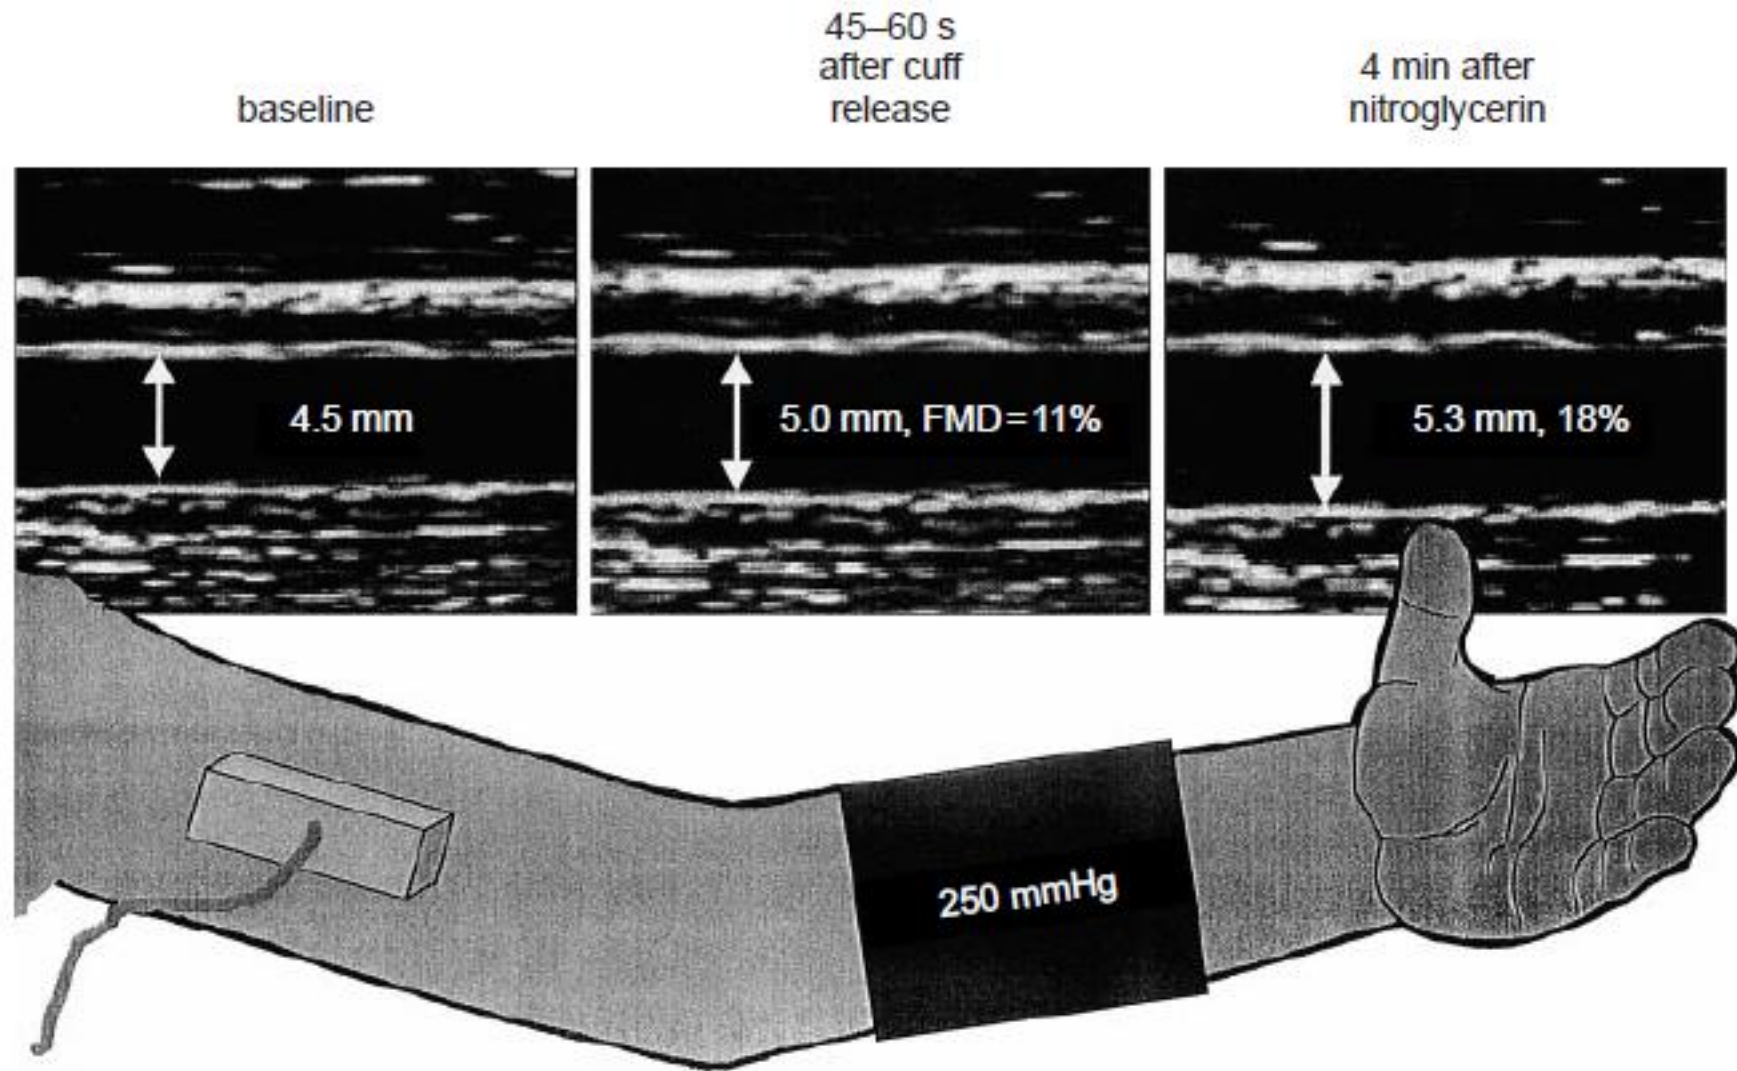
Brachial artery diameter is measured during three conditions; baseline (after at least 10 min supine rest), during reactive hyperaemia (induced by inflation to 250 mmHg and then deflation of a sphygmomanometer cuff around the forearm) and finally after the administration of sublingual nitroglycerin. A linear array, high resolution ultrasound transducer is used to provide B-mode images of the target vessel, proximal to the forearm cuff. FMD = flow-mediated dilatation.
